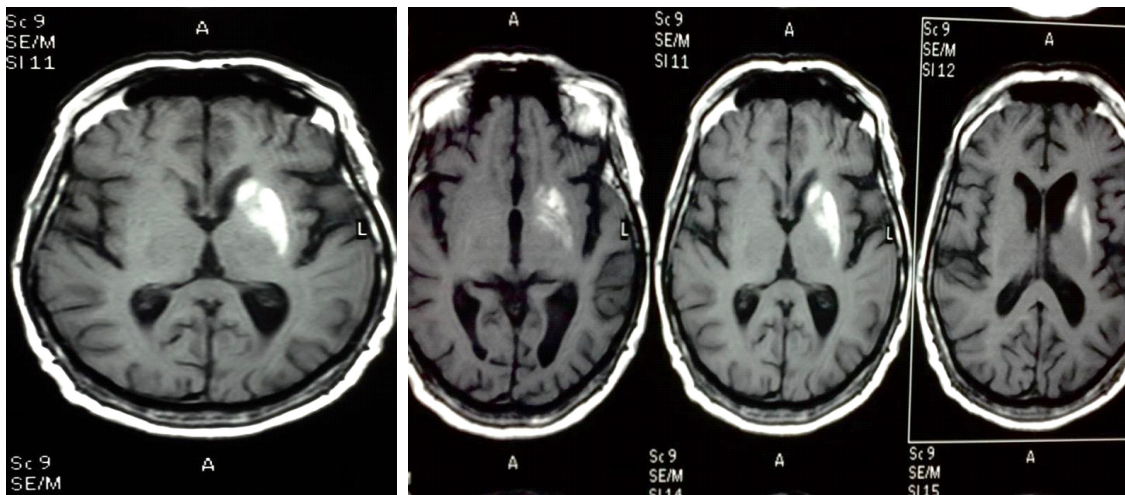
Axial T1-weighted nuclear magnetic resonance image in axial plane at the level of the basal nucleus where there is evidence of increased signal intensity in the head of the caudate nucleus and part of the posterior arm of the internal capsule.
